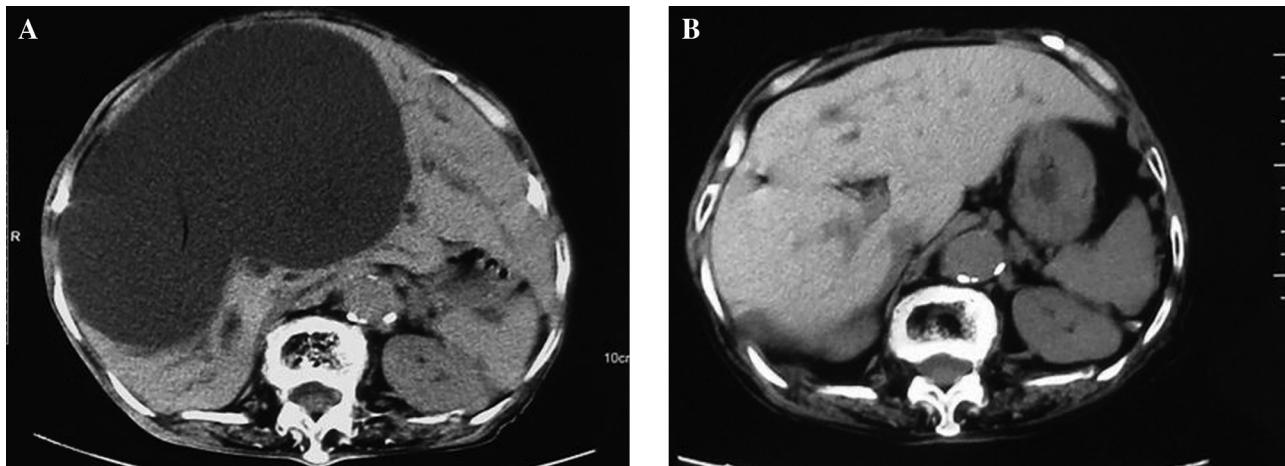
Representative CT images of an 83-year-old female patient with an SHC treated by repeated rapid alcohol-instillation sclerotherapy. Transverse CT images were obtained (A) before treatment and (B) six months after repeated rapid alcohol-instillation sclerotherapy.
